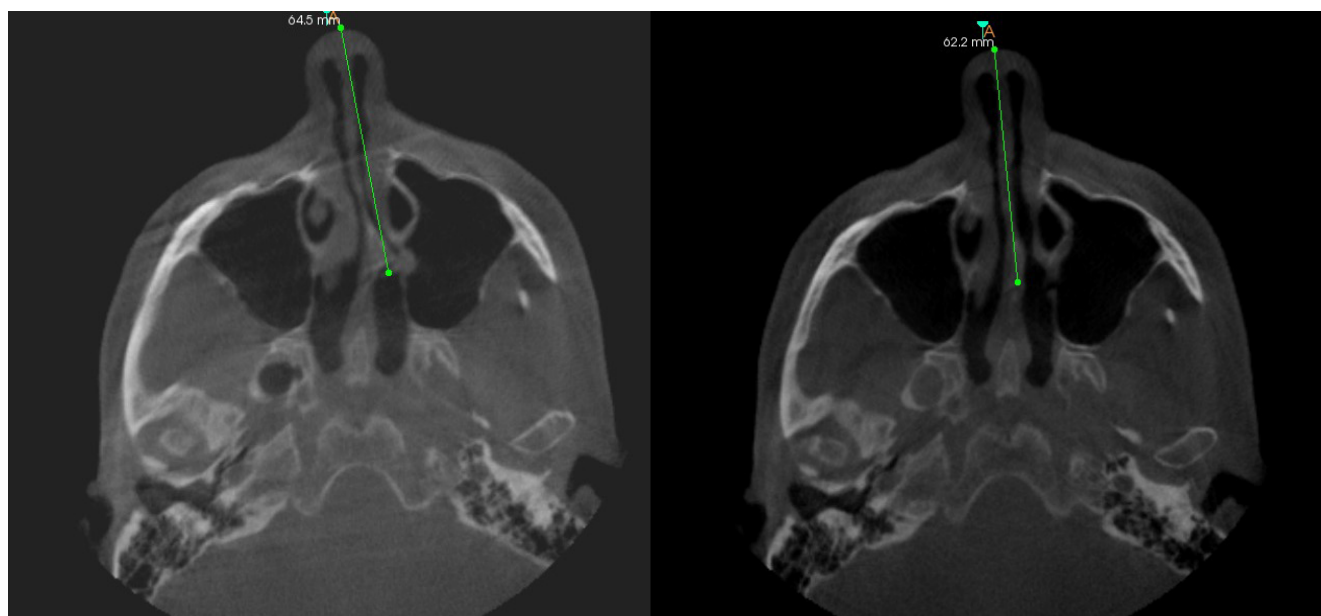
Pre-operative and post-operative axial CT shows septal deviation at PMD. Pre-operative (left) CT scan shows significant septal deviation with a PMD of 65.60 mm from the midline. Post-operative (right) scan demonstrates improved septal alignment following CNB-assisted septoplasty.
